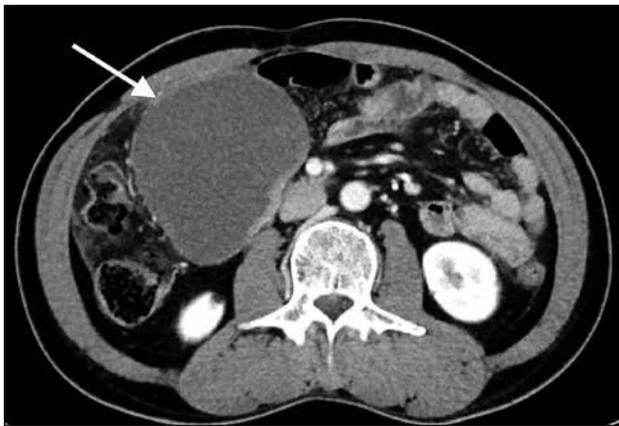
Mesenteric gastrointestinal stromal tumour in a 69-year-old man. Contrast-enhanced computed tomography showing a large well-defined mesenteric mass with central low attenuation (arrow) that does not have obvious connection with the bowel.
